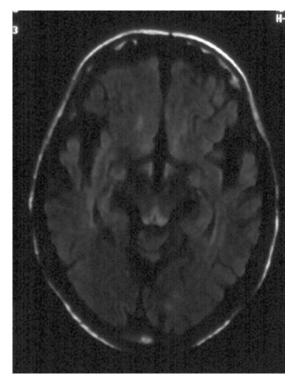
weighted fluid-attenuated inversion recovery axial brain MRI showing abnormal hyperintensity in the periaqueductal gray matter at the level of the midbrain and surrounding the third ventricle.
